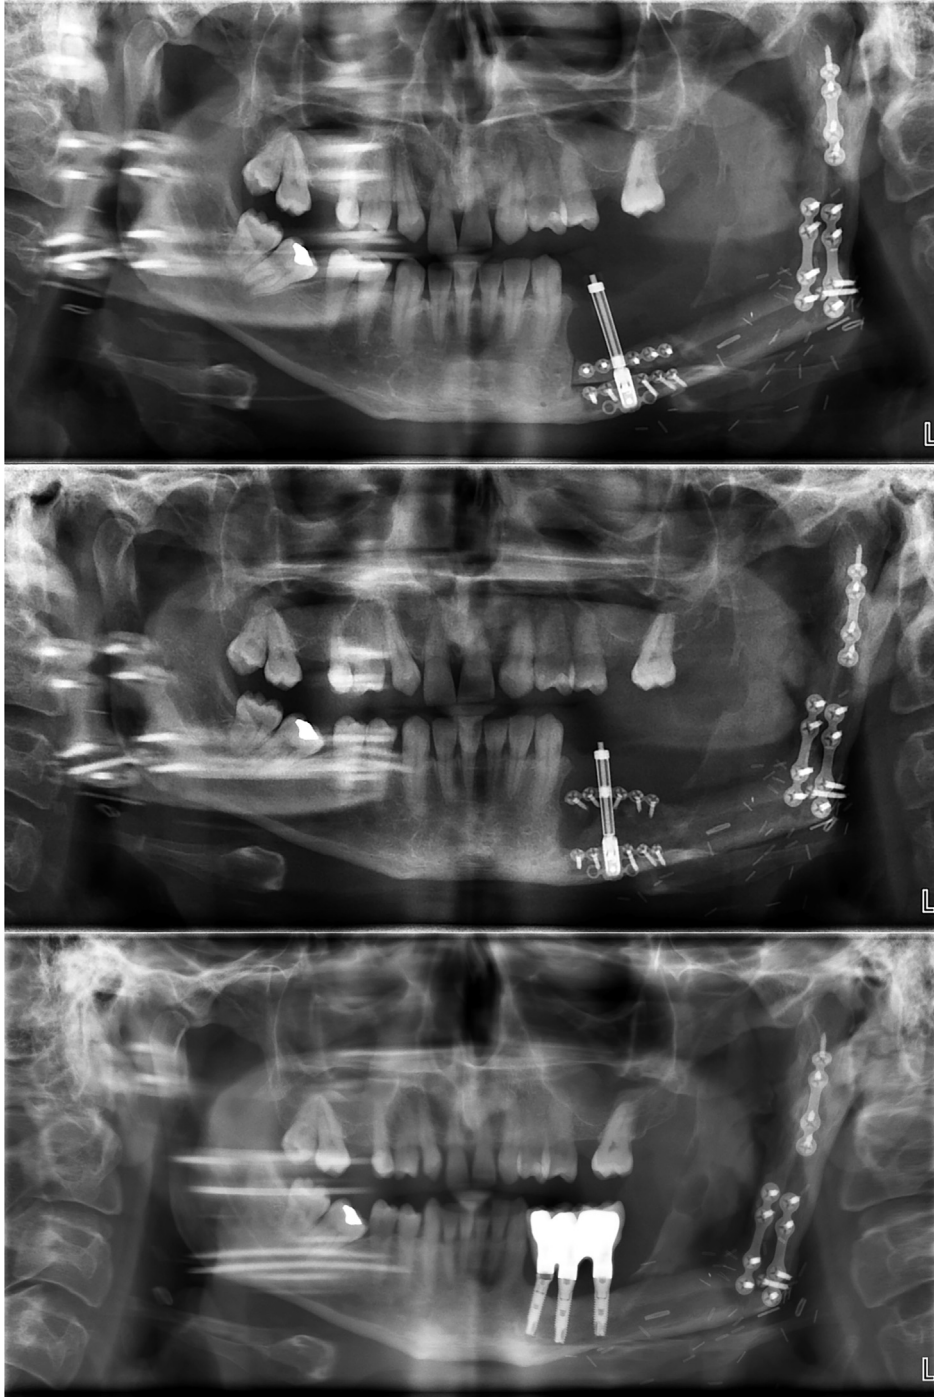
Case 1. Panoramic x-ray images. Top: at the beginning of osteodistraction; Middle: at the end of osteodistraction; Bottom: at the 8-year follow-up.
